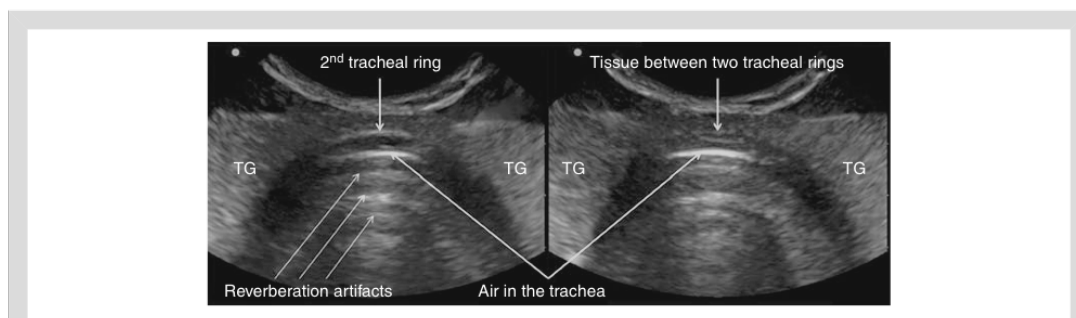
Ultrasound scan in a transversal axis with the probe placed in the jugular depression. TG, thyroidal gland.
